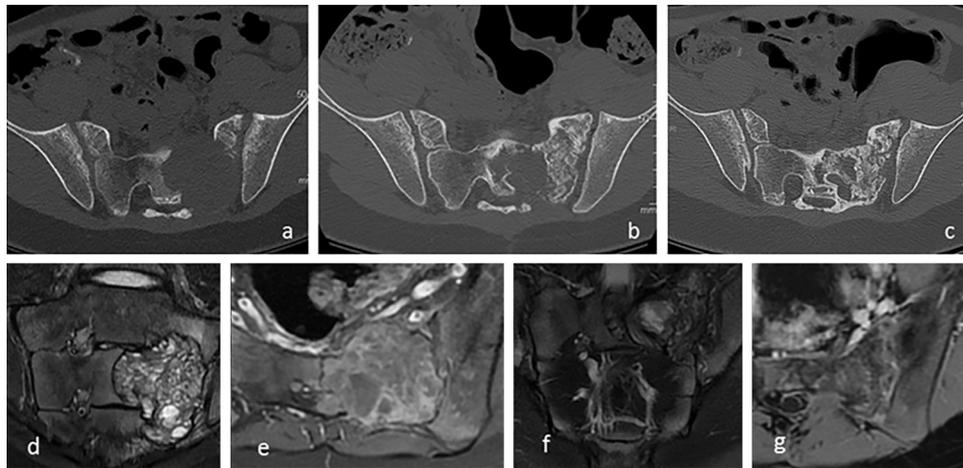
Patient #2 a, b, and c: Computed tomography scans, (a) at diagnosis, (b) 6 months after denosumab initiation showing mineralisation of the lesion in a centripetal direction, and (c) 10 months after denosumab initiation showing cortico-medullary dedifferentiation and cortical thickening with no change in size (RECIST); d, e, f, and g: Magnetic resonance imaging, T2-weighted coronal view and T1-weighted axial view; (d and e) before denosumab therapy, cystic images with fluid-fluid levels indicating the presence of blood, with contrast enhancement of the lesion; (f and g), 10 months after denosumab initiation, the cystic images and fluid-fluid levels are no longer visible and the contrast enhancement is less marked.
